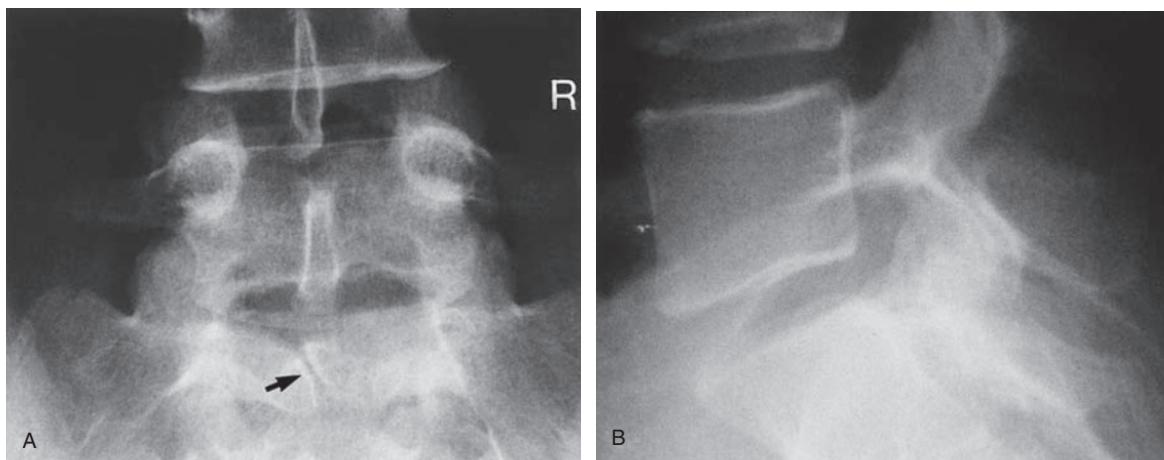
(A) Lumbosacral anteroposterior plain X-ray image. Note the spina bifida occulta at the S1 level (black arrow). R = right side of patient. (B) This lateral lumbosacral plain X-ray image did not show any abnormality.
